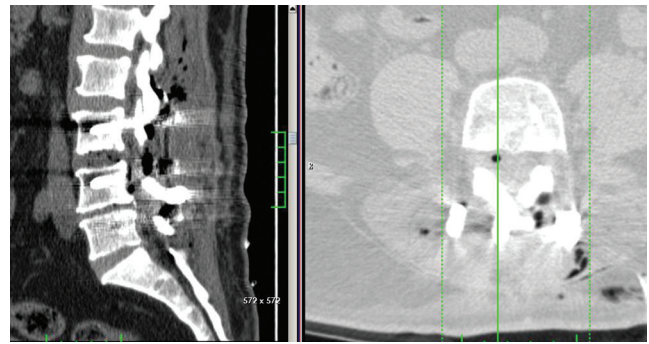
Sagittal reformation of the postoperative lumbar computed tomography in soft tissue window (left) and transverse cut from the L4 level at lung window (right) showing air densities in L3-4 intervertebral space, anterior-right to the dural sac, and in the posterior extradural regions.
